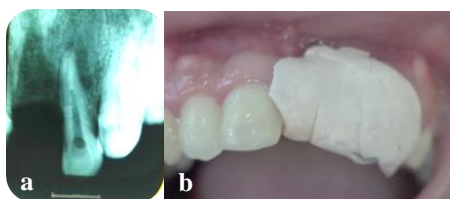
(a) Radiograph examination to confirm the materials placement, (b) periodontal pack dressing at postsurgical area.
